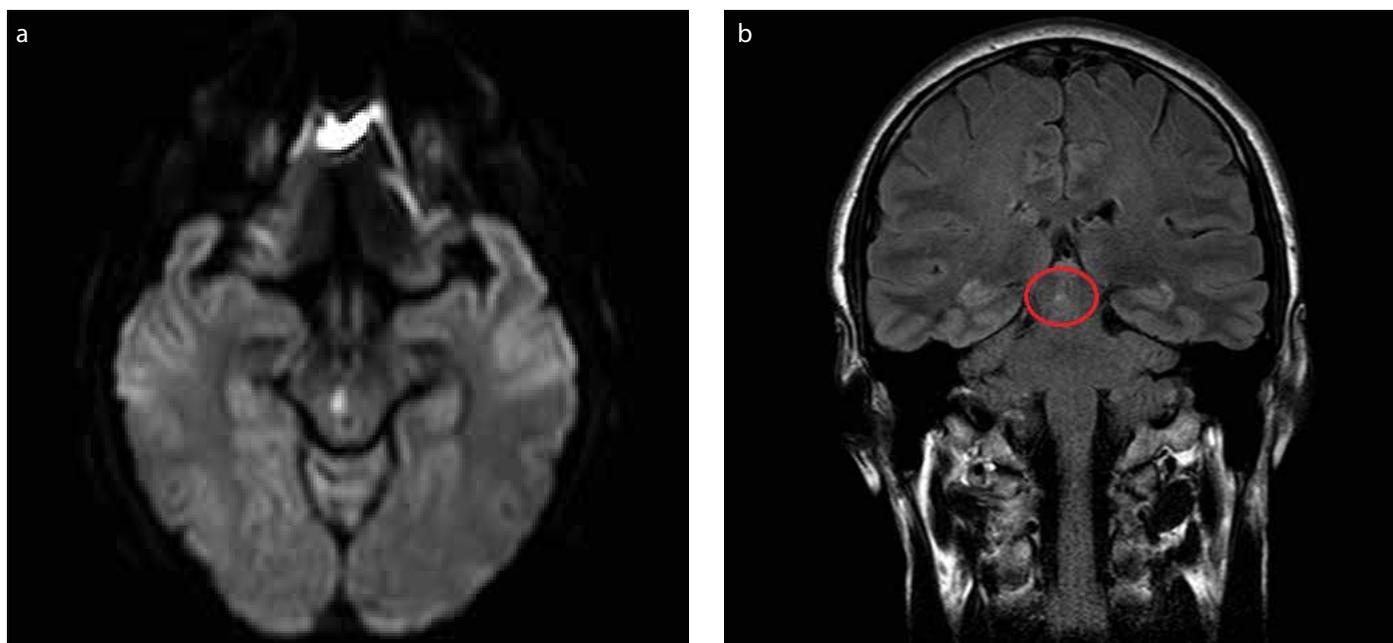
a, b. Clearly demarcated zone of high-intensity signal in the medial aspect of the right mesencephalic roof on diffusion-weighted (a) and FLAIR sequences (b) consistent with recent lacunar infarction
